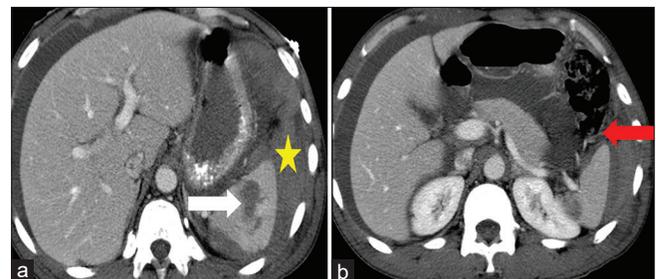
A 29-year-old woman with tubo-ovarian abscess. Computed tomography abdomen axial image with IV contrast demonstrating an abscess within the immediate left subphrenic space (star). The white arrow indicates the gastrohepatic ligament.
